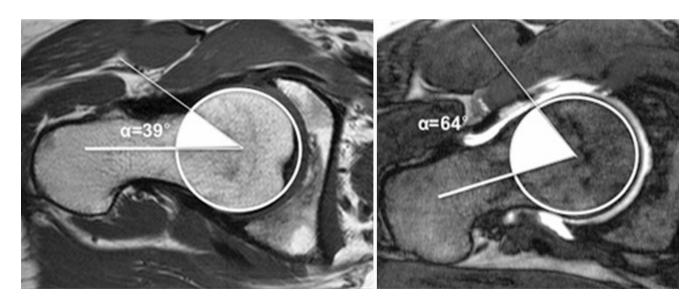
Axial MRI of normal (*left*) and FAI hip (*right*) to demonstrate measurement of the alpha angle
